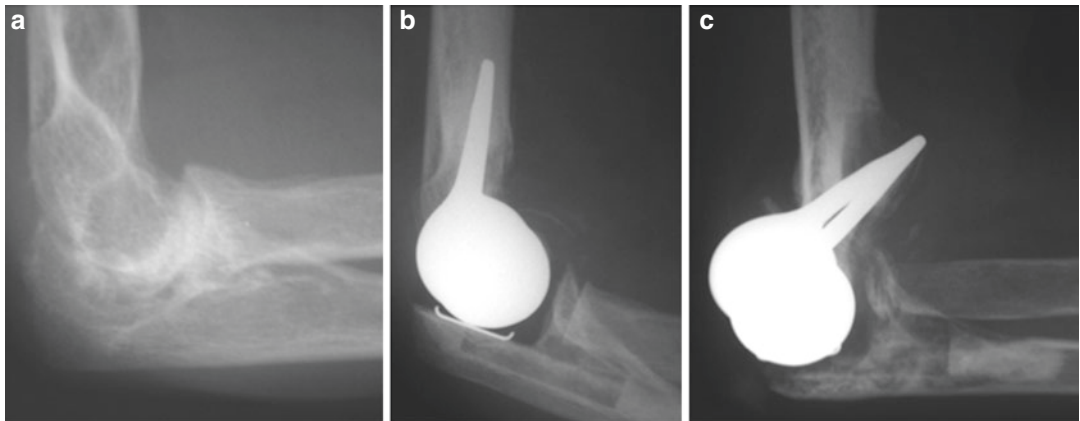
(a) Lateral radiograph of a patient with rheumatoid arthritis, (b) postoperative radiograph after a short stem TEA (Souter-Strathclyde, Stryker), (c) humeral loosening with implant failure at 5 years
